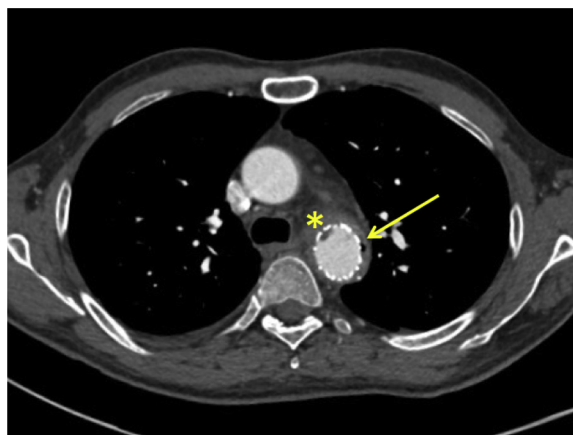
Air between the endograft and native wall of the aorta (*arrow*) and a vegetation adhering to the aortic endograft (*star*) are demonstrated on a preoperative axial computed tomography angiography scan.
